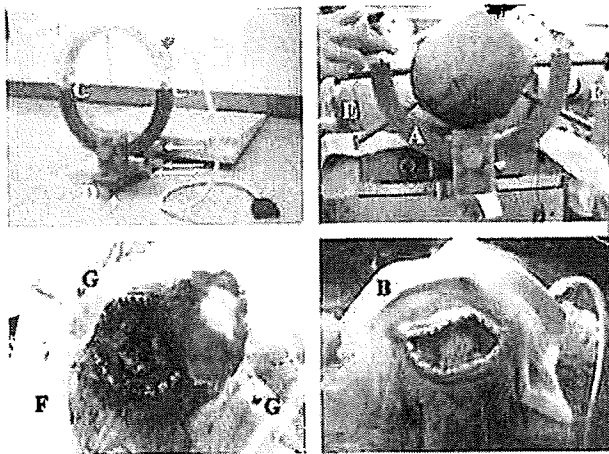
Radiofrequency receiver coil integrated with a modified Sugita head holder for intraoperative MRI (Head-holder coil; Mizuho Ltd., Tokyo, Japan): general view of the device (upper left), fixation of the patient's head within a modified Sugita head holder before craniotomy (upper right) and during the surgical procedure (lower left), connection of both semicircular arches before intraoperative imaging, which provides a solenoid coil structure (lower right). Marked: modified Sugita head holder with built-in copper wire (A), removable upper semicircular arch (B), electrical connectors (C), supporting arm for fixation to the operating table (D) with its 3 joints (solid arrows) and 2 rotational axes (dashed arrows) for adjustment of the position of the patient's head, titanium fixation pins (E), sterile surgical drapes (F), sterile protective caps, covering the electrical connectors during surgery (G).
